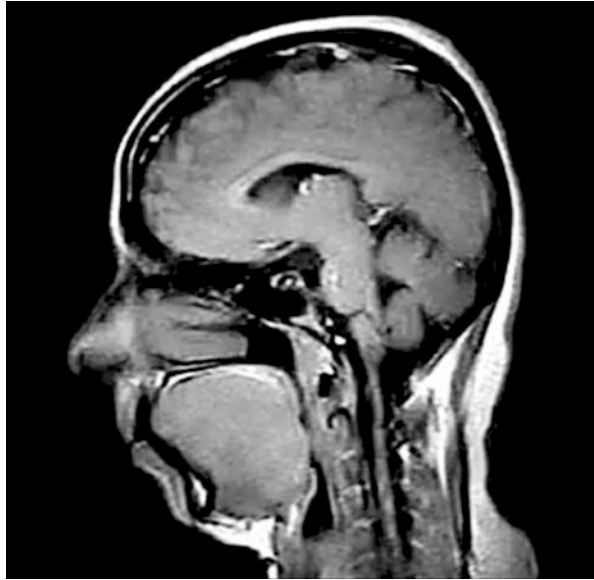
Dynamic MRI of an OSAS patient showing tongue base hypertrophy
